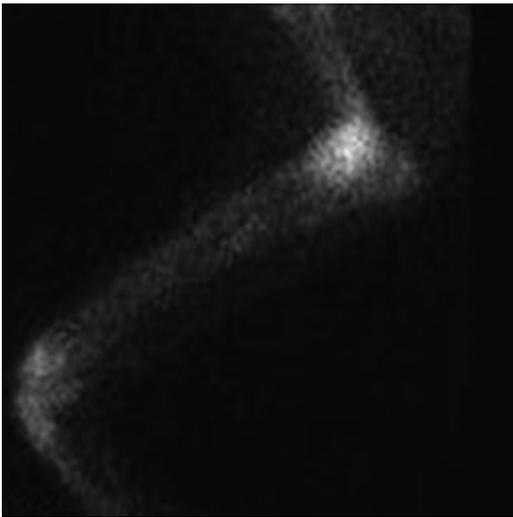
Nuclear scintigraphy scan showing diffuse uptake of the elbow joint.
